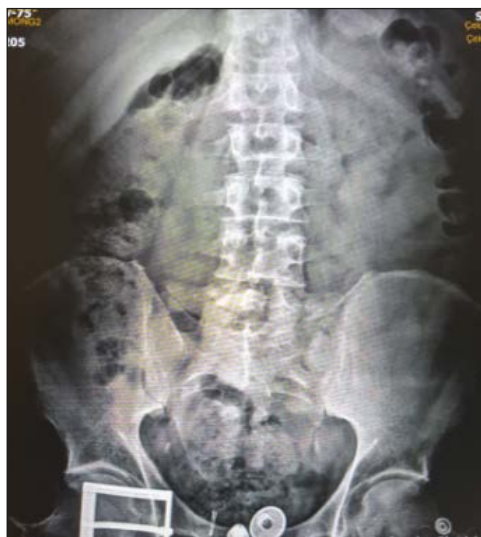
Bilateral enthesopathic changes of the superior posterior iliac spine and sacroiliitis, with sclerosis and widening of joint spaces on lumbosacral X-ray imaging.
